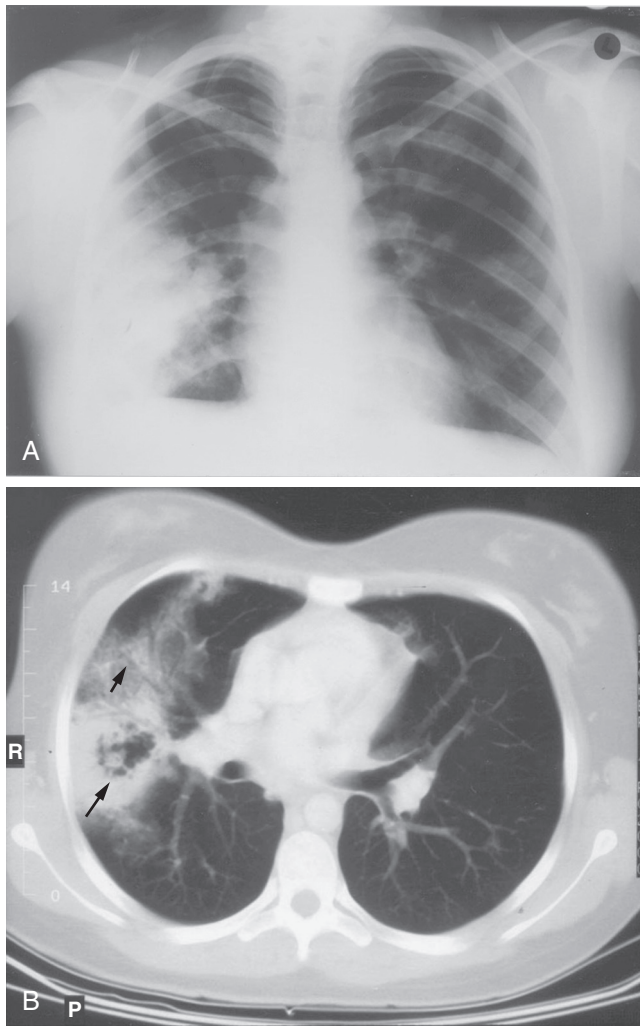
A, Chest x-ray film showing alveolar hemorrhage in the right (*R*) lung in a patient with Granulomatosis with polyangiitis (Wegener granulomatosis). B, Chest computed tomography scan taken at about the same time showing an air bronchogram (*long arrow*), typical of alveolar hemorrhage, and cavitation in a nodule (*short arrow*).
